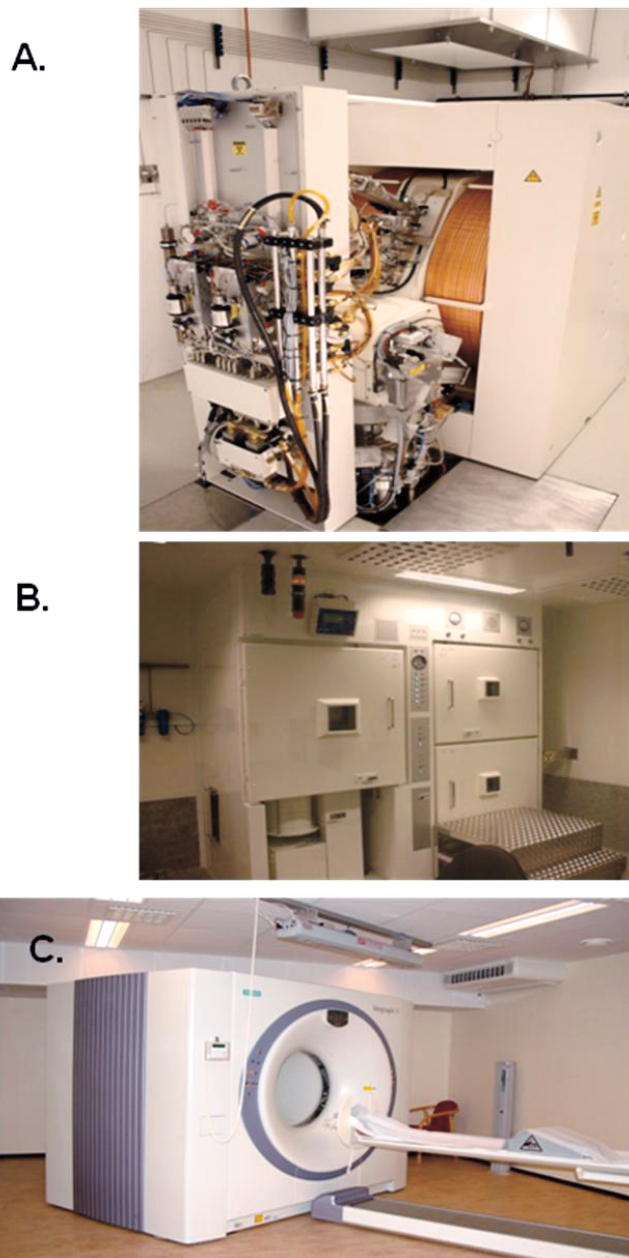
A: The cyclotron at Oslo University Hospital (PETTrace 6, GE Healthcare Technologies). B: The clean room with the hot-cells for FDG production (Stacked Synthesis Cell SB2S, right, and Dispensing Hot Cell, left, Van Gahlen by Siemens Healthcare). C: The PET/CT scanner at Oslo University Hospital, The Norwegian Radium Hospital (Biograph 16, Siemens Healthcare).
